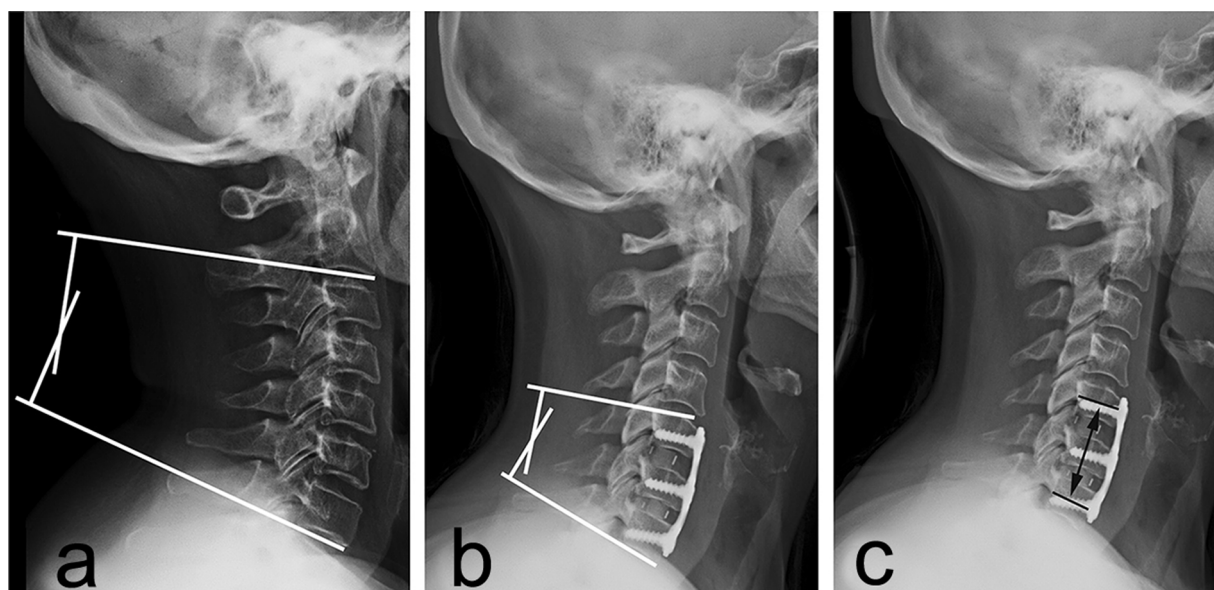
Lateral radiographs showing the radiological parameters. a: The cervical lordosis was defined as the angle formed between the lower endplate of C2 and the inferior endplate of C7 using Cobb's method. b: The segmental angle was defined as the angle formed between the superior endplate of the superior vertebra and the inferior endplate of the inferior vertebra of the fused segment using Cobb's method. c: Segmental height was defined as the distance between the midpoint of the cranial and caudal vertebrae involved in the construct.
